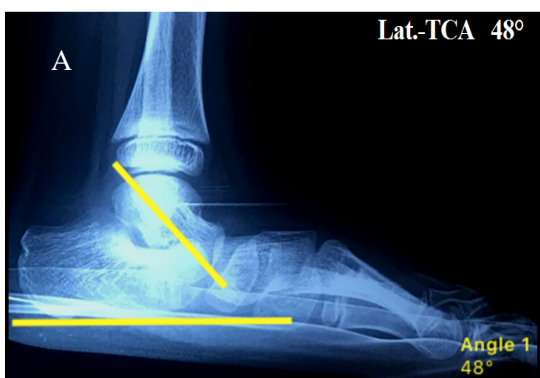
Radiographs showing measurement of preop. (A) and postop. (B) lat.-TCA angles.
